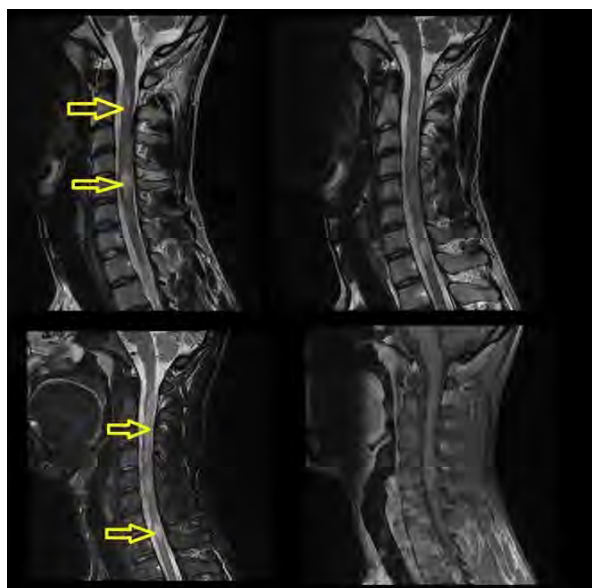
Baseline MRI scan of the cervical spinal cord in T2-weighted, STIR, and T1-weighted contrast-enhanced, sagittal plane. MS lesions in the spinal cord
